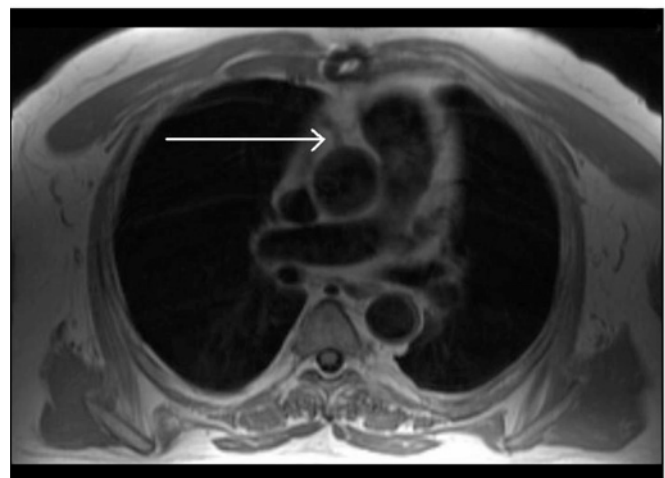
Magnetic resonance image. Axial black blood image through ascending aorta shows graft origin (arrow).
